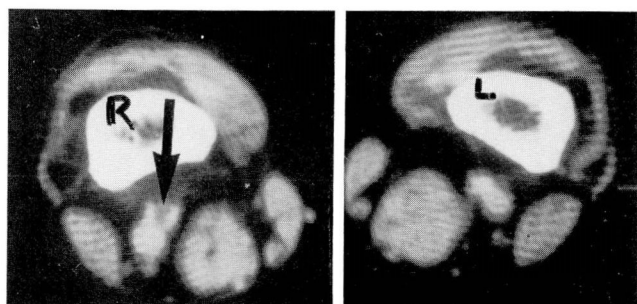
CT scan of the lower extremities after intravenous injection of contrast medium. A small lucent mass is seen in the anterior wall of the right femoral artery (arrow). Patient is supine (*R* = right femur, *L* = left femur).
